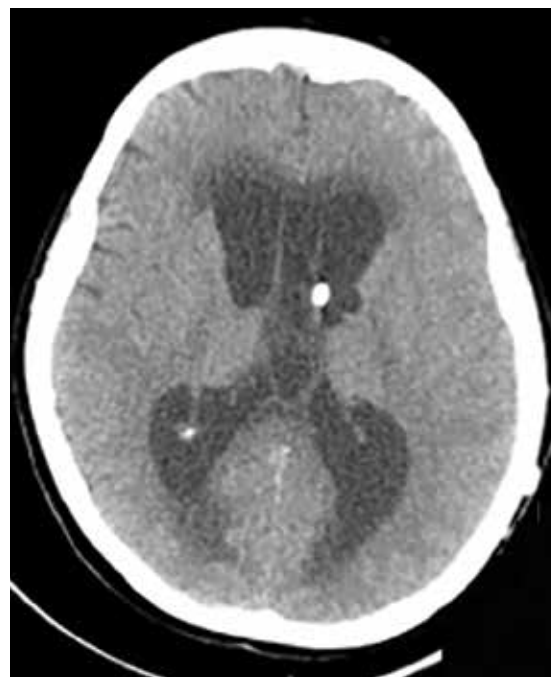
Preoperative CT scan showing hydrocephalus with transependymal edema in a malfunctioning left ventriculoperitoneal shunt
